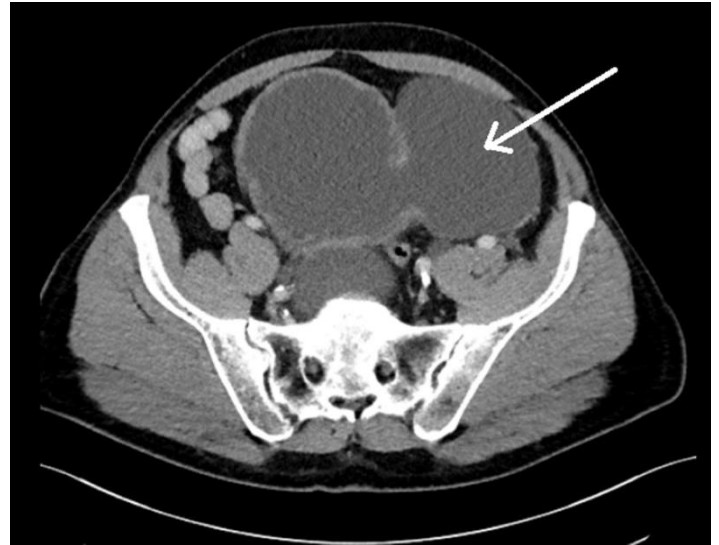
An axial computed tomography scan showing the diverticulum located at the left wall of the urinary bladder (white arrow).
